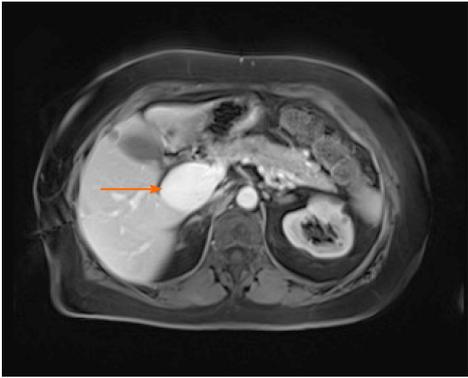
Contrast-enhanced magnetic resonance imaging of the abdomen of Case 2. The axial image showed saccular extrahepatic aneurysmal dilatation of the portal vein (arrow).
